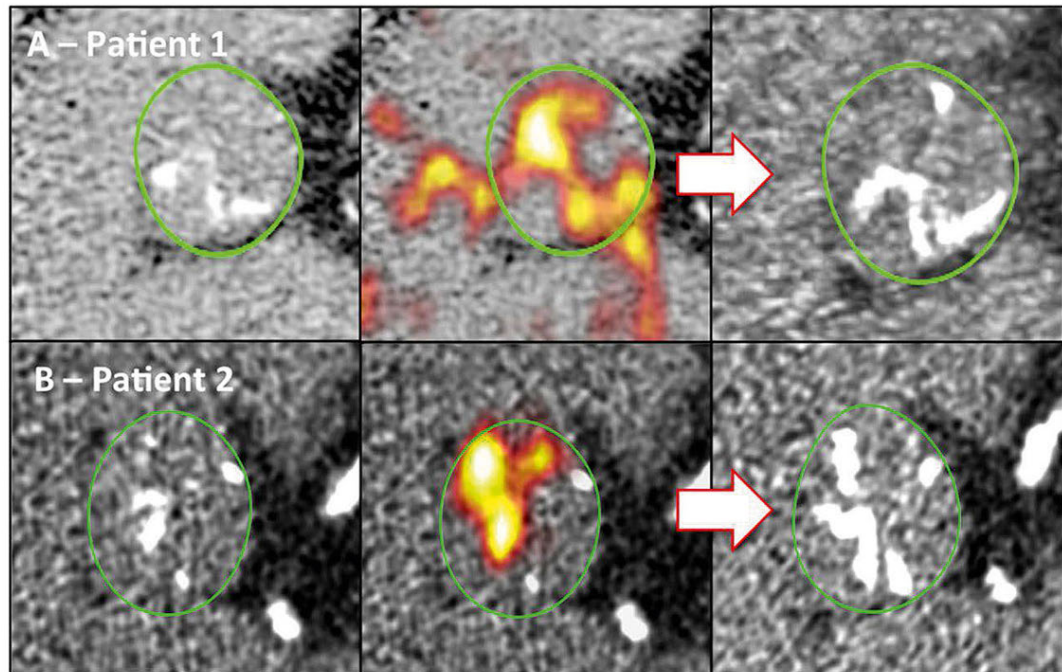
Baseline CT calcium scores (left) for patients 1 and 2 (top and bottom). Fused coaxial ¹⁸F-fluoride PET-CT scans (middle) show fluoride uptake in red and yellow. The 1-year follow-up (right) suggests that the baseline PET signal predicts the spatial distribution of subsequent macrocalcification. (Dweck *et al*, 2014)
